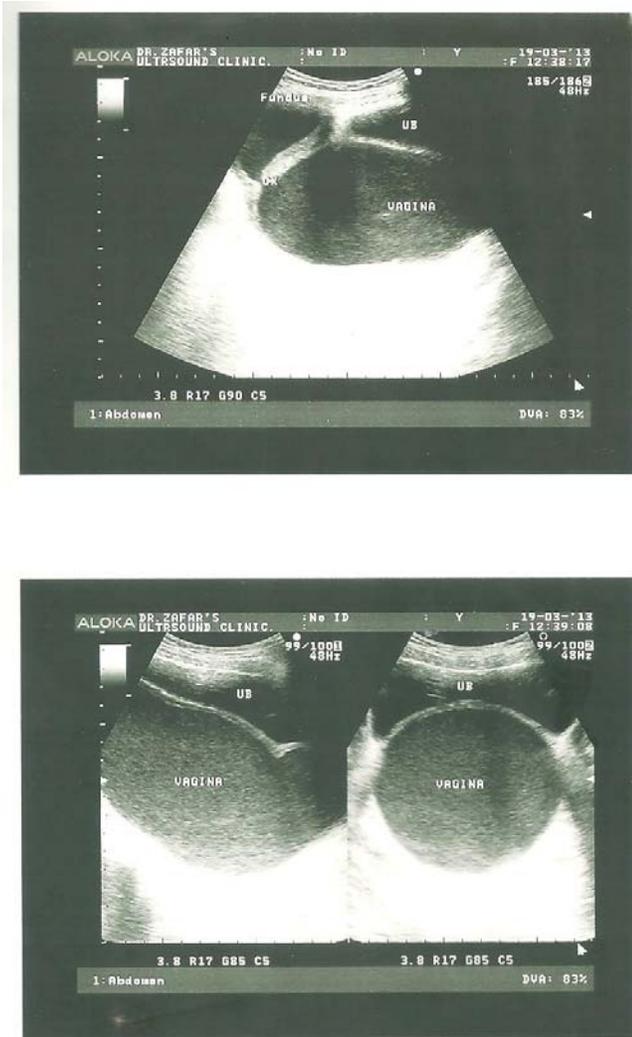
Ultrasound Picture on Second Consultation: S₂
